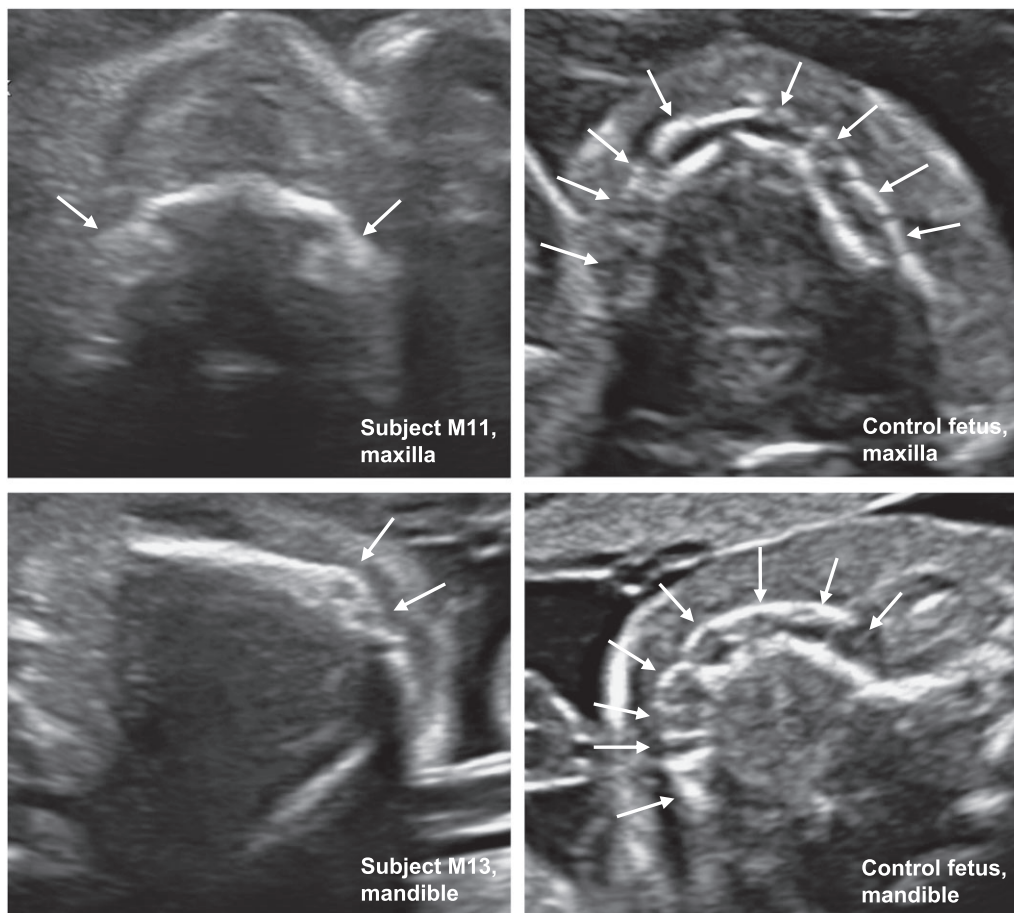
Prenatal sonographic screening for X-linked hypohidrotic ectodermal dysplasia (XLHED). In healthy controls (upper and lower right panel), axial sections of alveolar bones show a normal number of tooth germs, represented by round hypoechogenic structures that are arranged in an arch-like fashion in the alveolar bone and highlighted by white arrows. In fetuses with a reduced number of tooth germs in the maxilla (upper left panel: fetus M11 at 21 weeks of gestation) or in the mandible (lower left panel: fetus M13 at 23 weeks of gestation), XLHED was diagnosed. Lack of tooth germs was accompanied by a thin, hypoplastic alveolar bone
